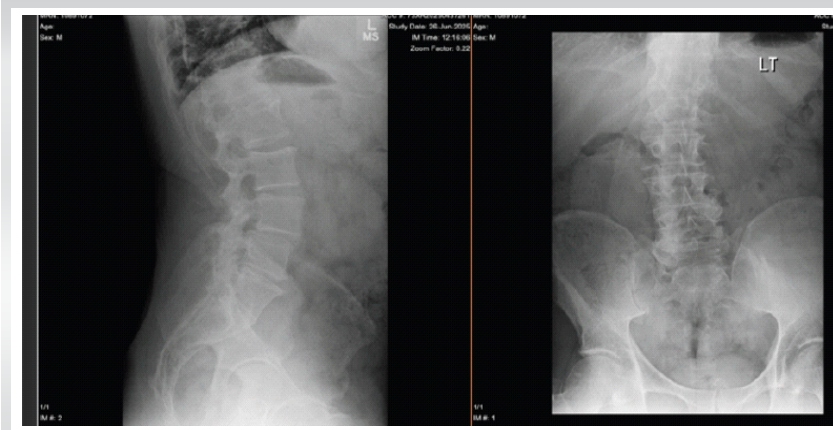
Anterior-posterior and lateral plain radiographs of the lumbar spine showing transitional lumbosacral morphology as well as advanced degenerative disc disease, particularly at the L5-S1 segment.
